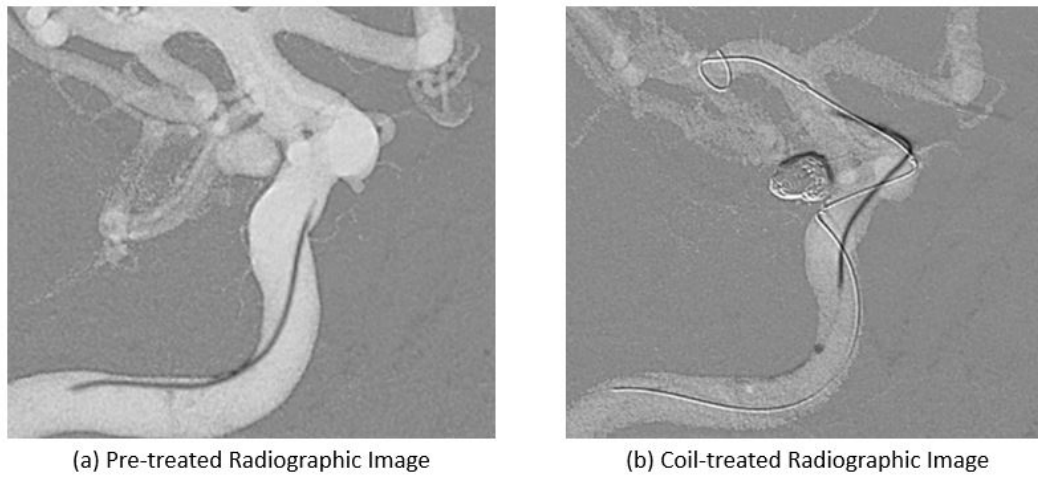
Radiopaque 2D imaging captured before (a) and after (b) coil deployment shows the catheter, device (in (b) only), and Doppler ComboWire.
